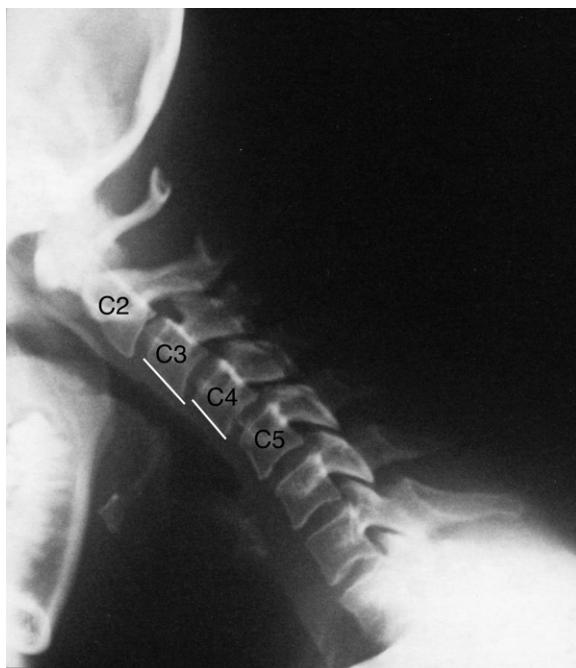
Cervical spine flexion plain X-ray image. Note the loss of normal contour with some angulation at the C4–5 level and anterolisthesis (see lines) of C3 on C4 and of C4 on C5.
